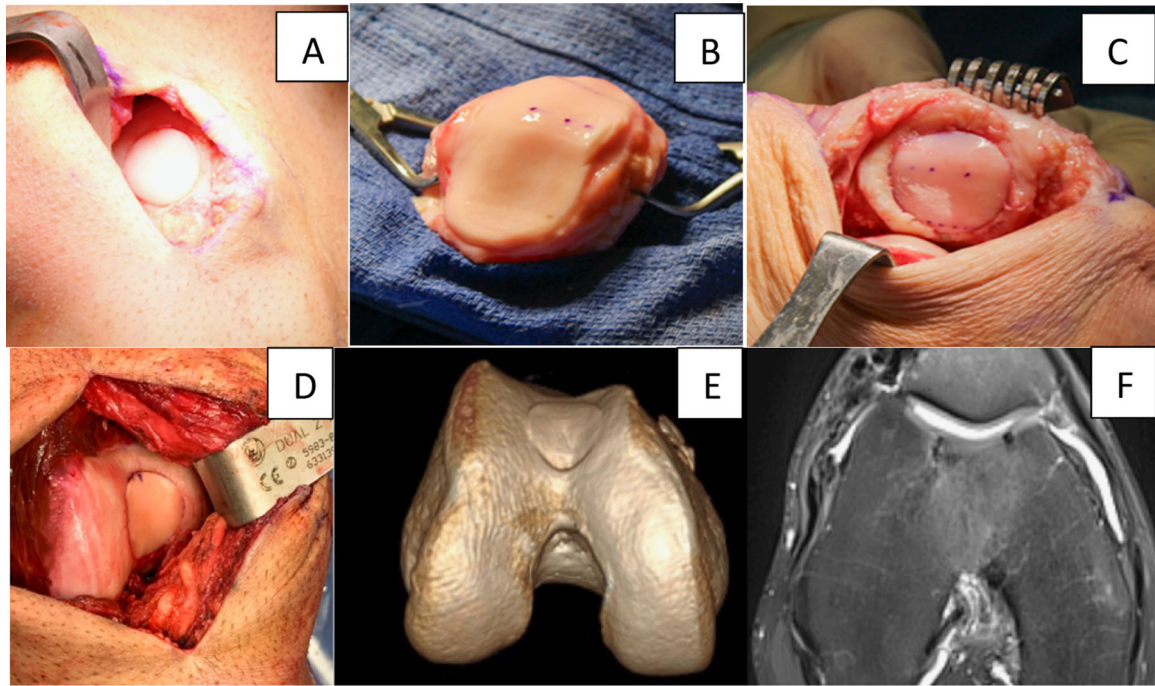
(A) Completed OCA transplantation of the medial femoral condyle. (B) Donor patella. (C) Completed OCA transplantation of the patella. (D) Completed OCA transplantation of the trochlea. (E) Postoperative 3D CT reconstruction of the trochlea. (F) Postoperative axial MRI demonstrating anatomic integration of a trochlea OCA. Figure 12D has been reproduced from Dasari et al. [118] with permission of the publisher.
